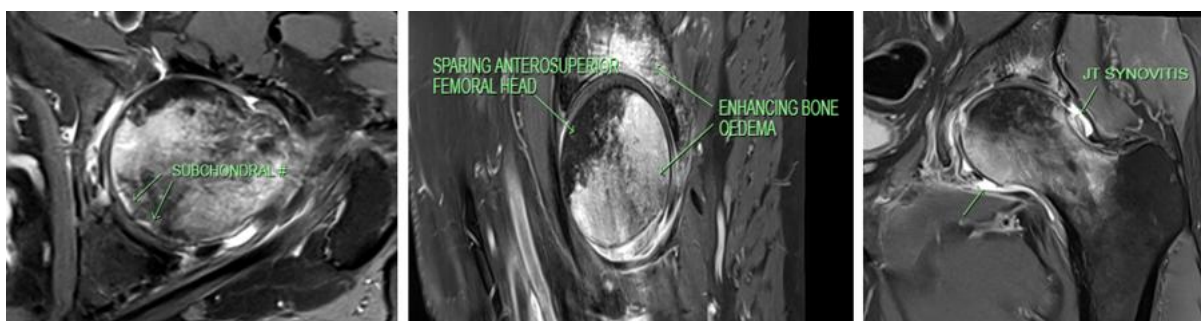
MRI of the left hip showing bone-marrow oedema, subchondral fractures and reactive synovitis consistent with transient osteoporosis.
